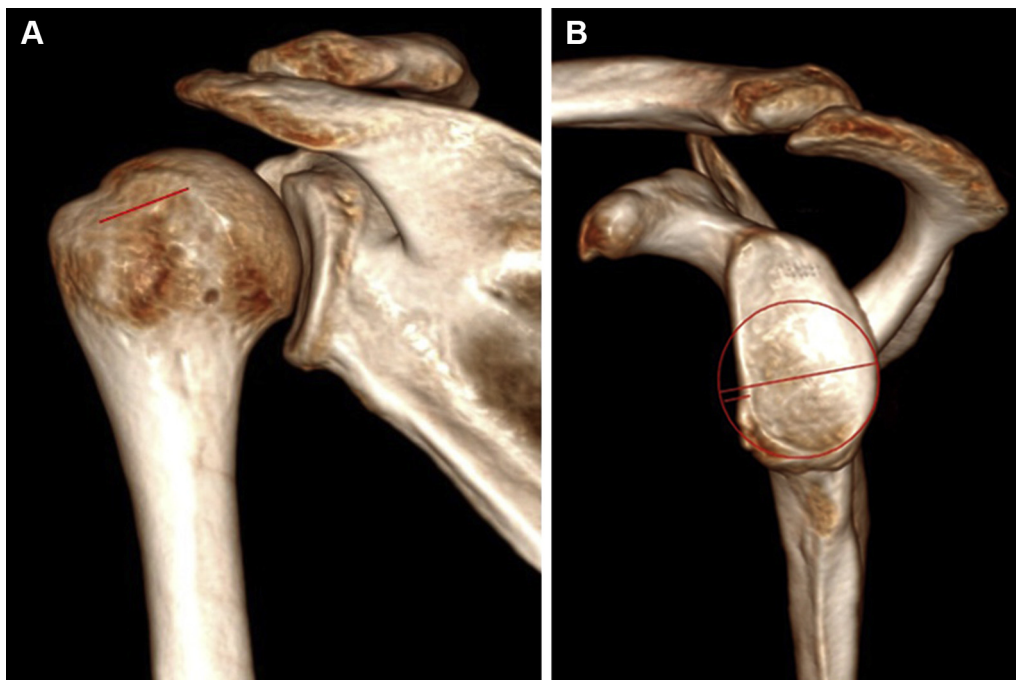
Three-dimensional computed tomography images demonstrating the calculation of GT. (A) The Hill-Sachs interval corresponds to the distance between the inner margin of the footprint of the rotator cuff and the medial border of the bone defect. (B) From a virtual circle traced in the lower two-thirds of the glenoid, having as reference its intact edges, we obtained the measure that would be the diameter of the same in the absence of the bone defect and the width of the bone defect. The GT corresponds to 83% of the glenoid diameter minus the value of the bone defect. *GT*, glenoid track.
